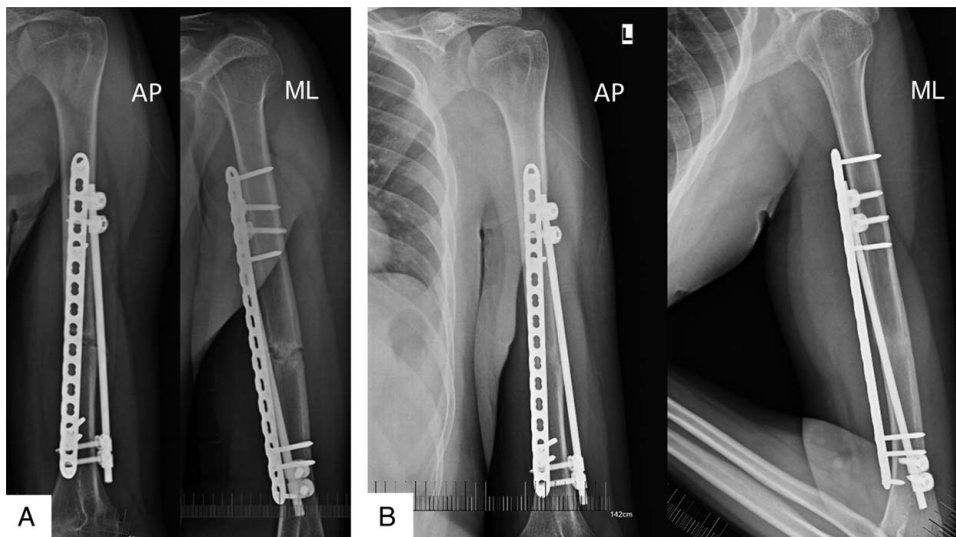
A plate combined with a rod could meet the need for an early and aggressive range of motion. (A) X-Ray at 6 months after surgery. (B) X-Ray at 18 months after surgery.
